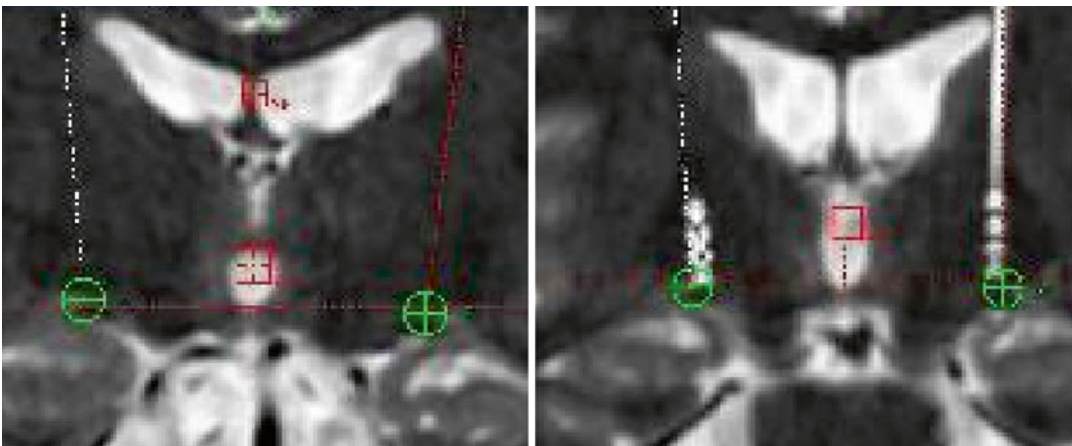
Left:* planning of GPi target. The target is just dorsal to the lateral edge of the optic tract. *Right:* Postoperative MR image showing accurate placement of the electrode
